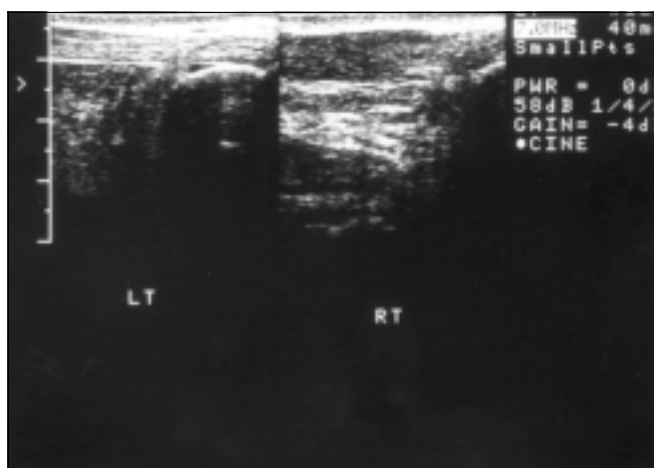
Longitudinal sonogram of a normal Achilles tendon (left) and Achilles tendinitis (right). Note thickening of the tendon.
